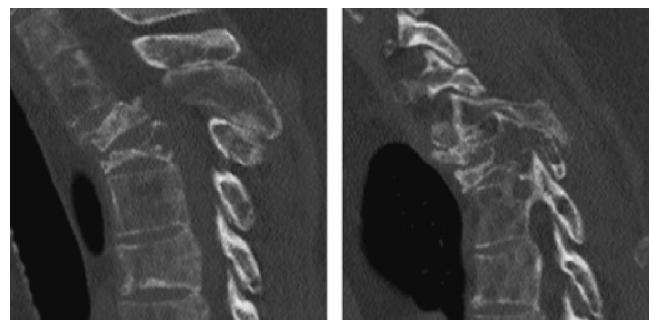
Sagittal CT images demonstrating new bone formation at anterior column and elongated or expanded spinous processes.
